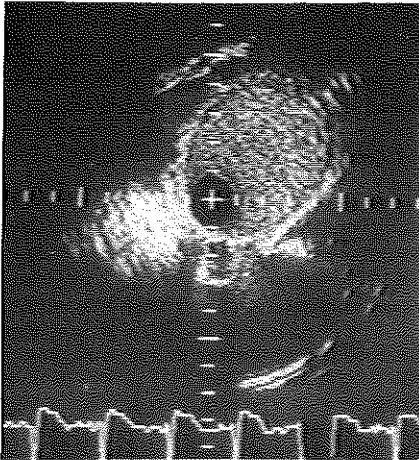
Intravascular ultrasound cross-section of a normal venous bypass-graft. The valves of the vein are clearly demonstrated. Calibration 1 mm.
